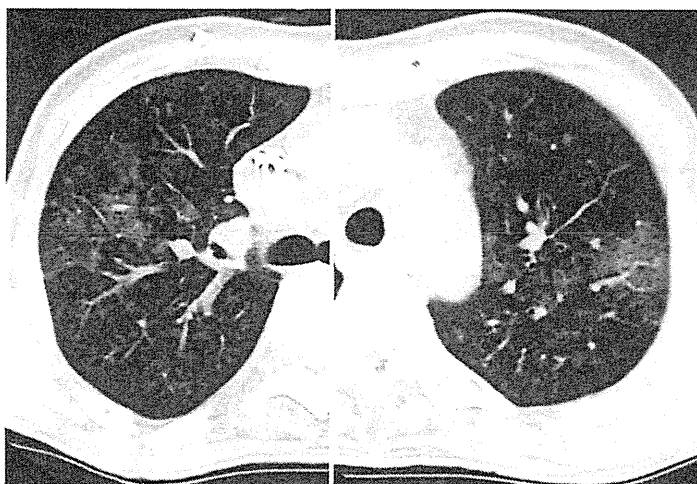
PVOD 症例の HRCT (図 5, 6 と別症例)
